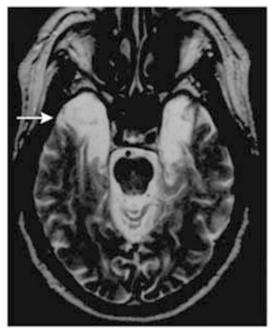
Horizontal section, from a transverse MRI (Magnetic Resonance Imaging) of HM's brain, showing the surgical lesion (Dickerson & Eichenbaum, 2009).
